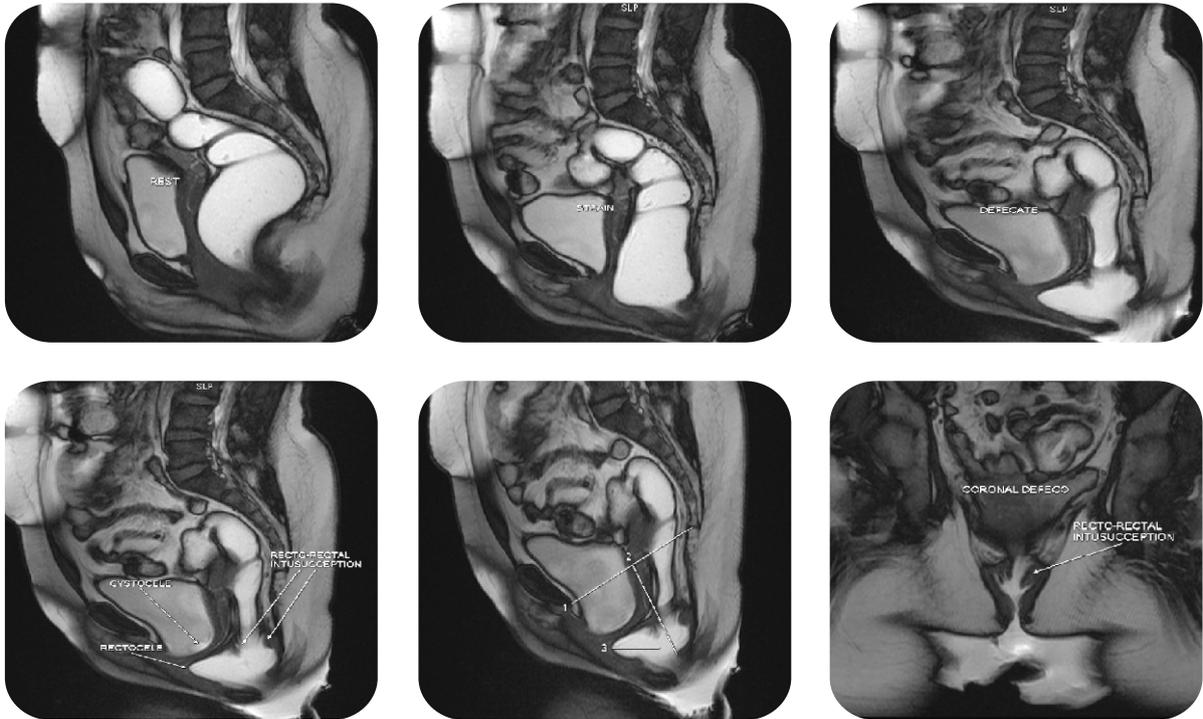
Image Courtesy of Alpha MRI – Mumbai
